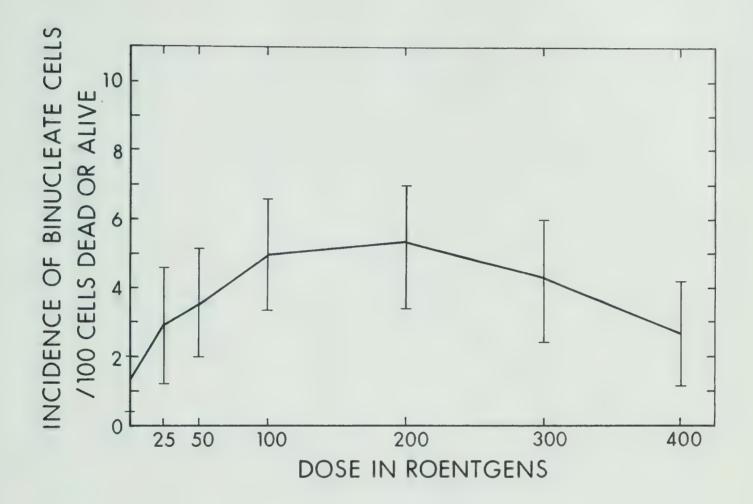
Effect of increasing single doses of X-rays, 0-400R, on incidence of binucleate cells in culture (72 hr. post-irradiation).
